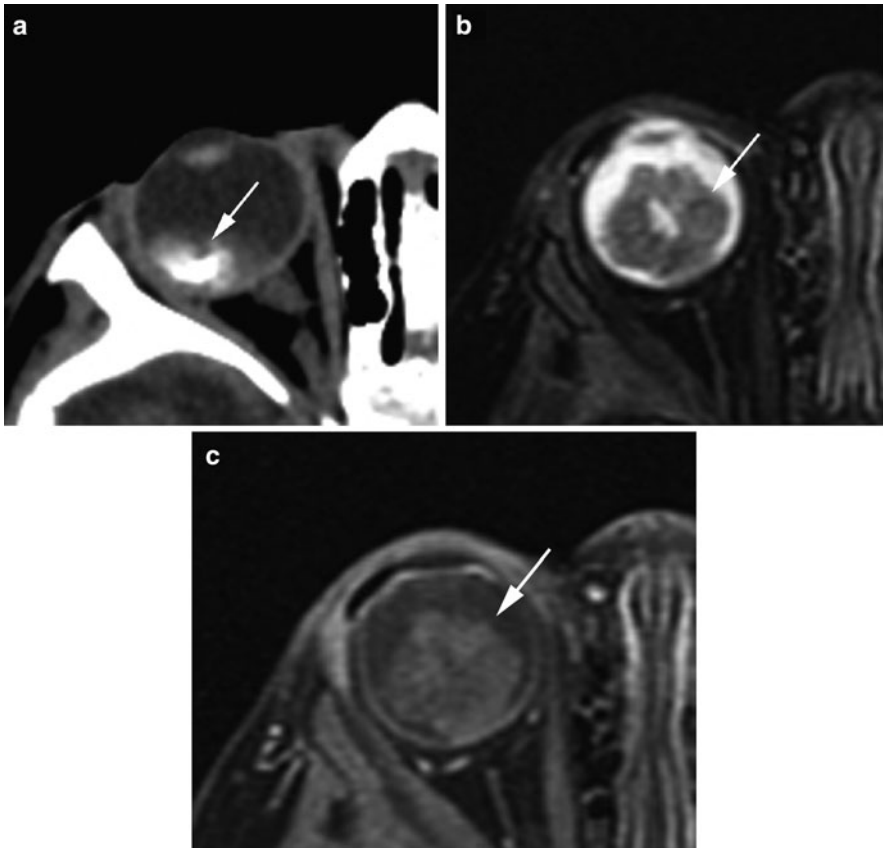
Retinoblastoma, right globe. (a) Axial precontrast-enhanced CT demonstrates a calcified mass in the right globe (*arrow*). (b) Axial T2 image shows a T2 hypointense mass extending into the vitreous (*arrow*). (c) Axial T1 postcontrast image with heterogeneous enhancement of the mass (*arrow*)
